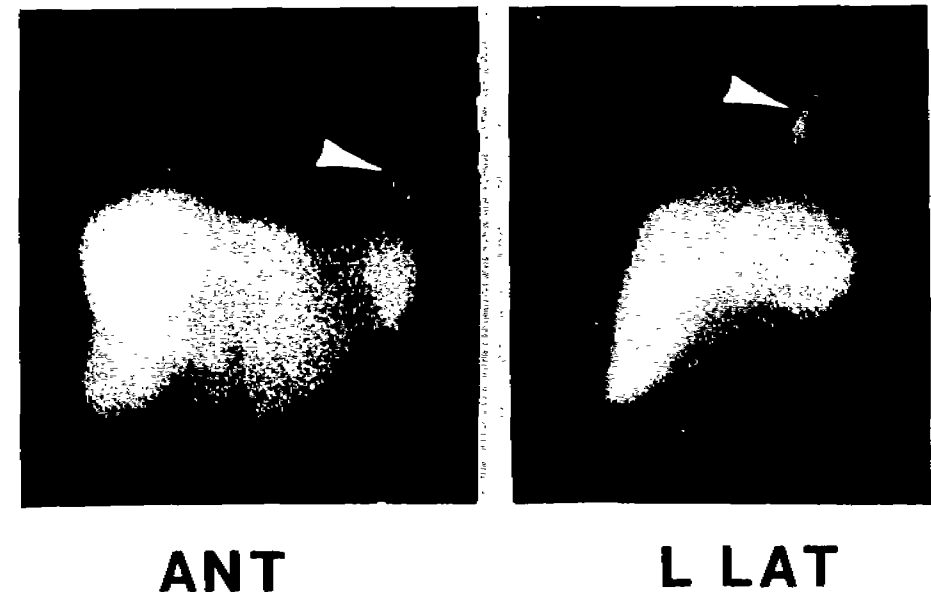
Anterior (ANT) and left lateral (L LAT) static images of liver and spleen made with ^{99m}Tc -labeled sulfur colloid show unusually prominent left lobe and abnormal focal activity (arrows) in the left lower lung posteriorly. Liver function tests and chest radiographs were normal.
